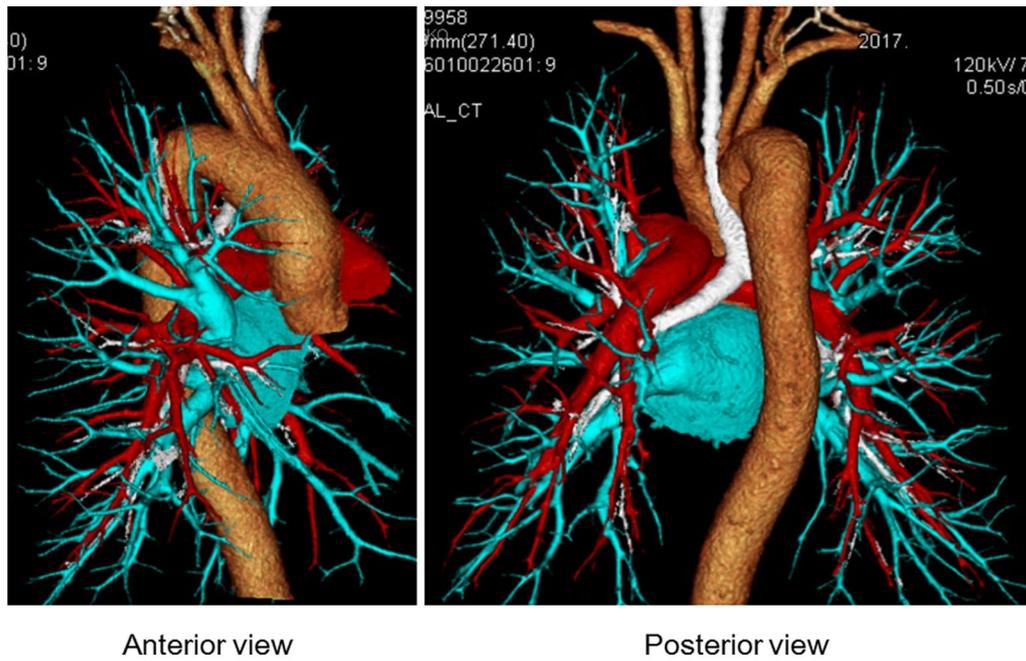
Three-dimensional computed tomography showed the right aortic arch (left, anterior view), and showed that the trachea was narrowed for long segments above and below the compressed site (right, posterior view)
